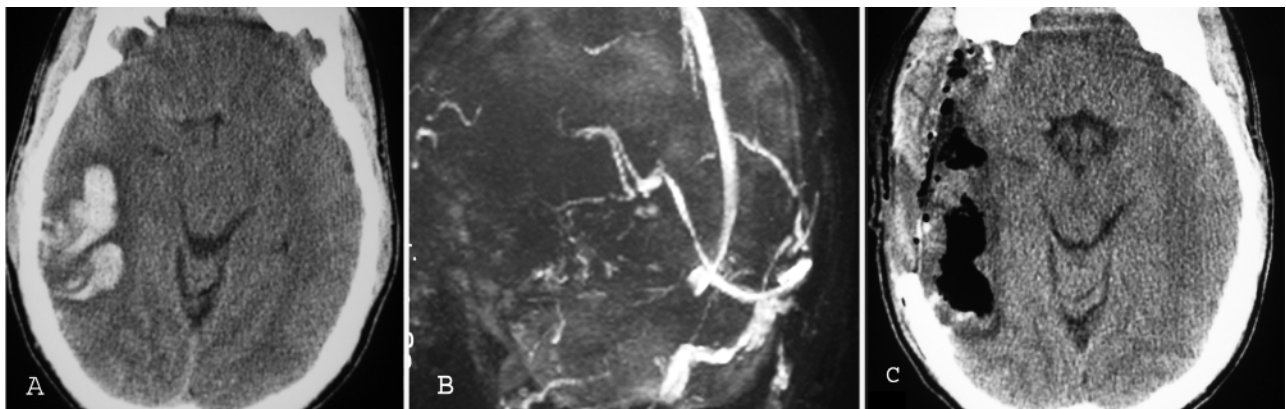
Case 3. A: Preoperative CT revealing a hemorrhagic infarction of the right temporal lobe with transtentorial herniation. B: An MR venogram showing absence of flow in the transverse sinus and Labbe vein on the right side. C: Postoperative CT of the brain.
